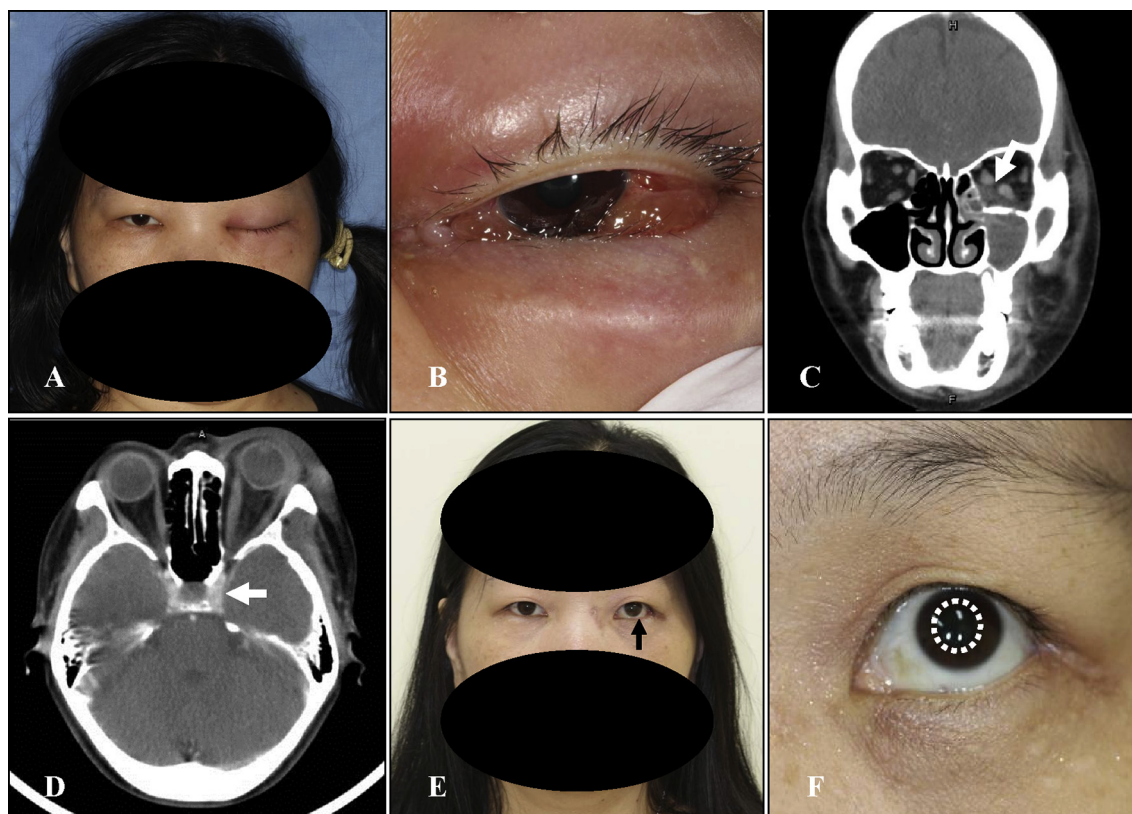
Clinical and radiographic photographs of the patient. (A) Severe swelling of the left face and ptosis of the left eye. (B) Chemosis of the left conjunctiva and cornea. (C) Coronal view of contrast-enhanced computed tomography. The left maxillary sinus is filled with fluid-like material, and the ethmoid sinus is affected. The arrow indicates extraocular muscle swelling and displacement. (D) Axial view of irregular enhancement and bulging along the left lateral side of the sella turcica (as indicated by the arrow). (E) At the 4-month follow-up, the swelling has subsided with little orbit decompression scarring. The black arrow indicates entropion. (F) Mild ophthalmoplegia is observed, particularly on upward gaze. The dotted line indicates mydriasis and no light perception in the left eye.
